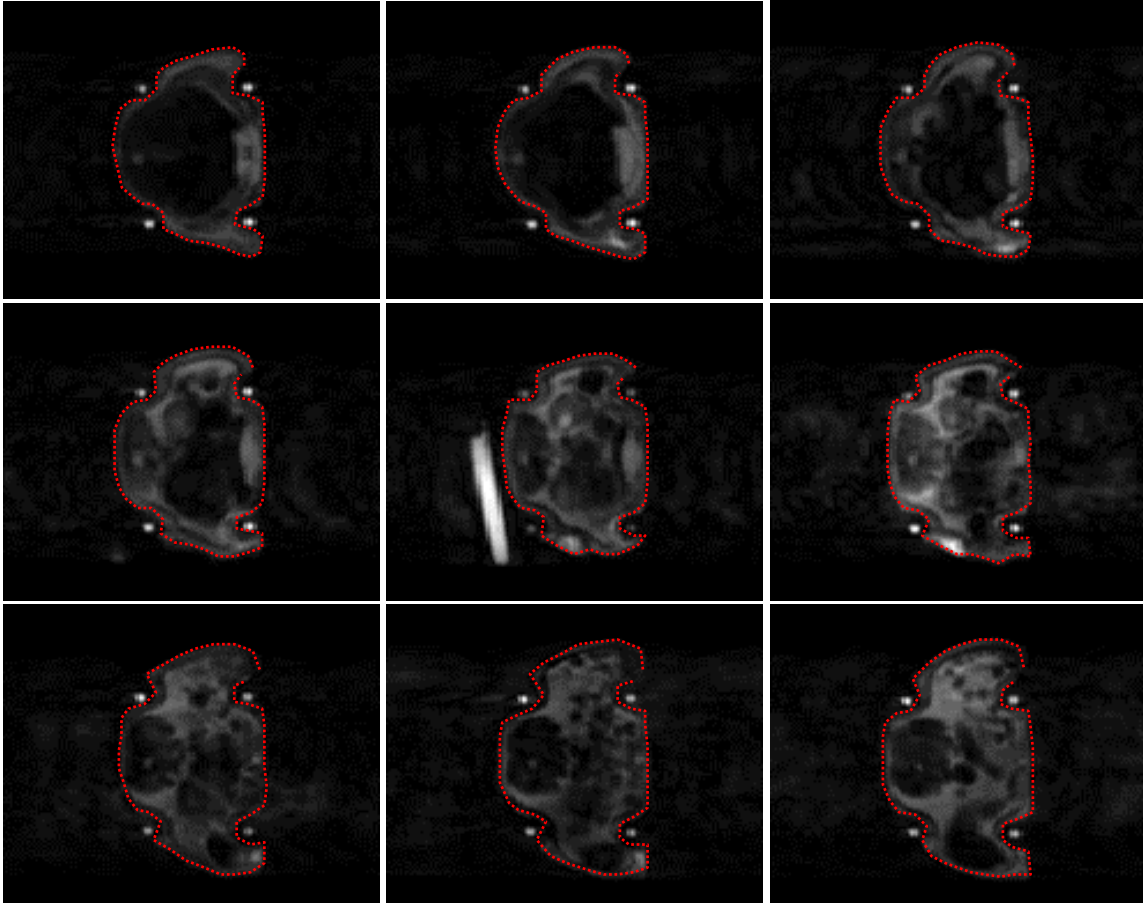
Multi-slice anatomical MR images and boundary points selected to generated the 3D geometry
